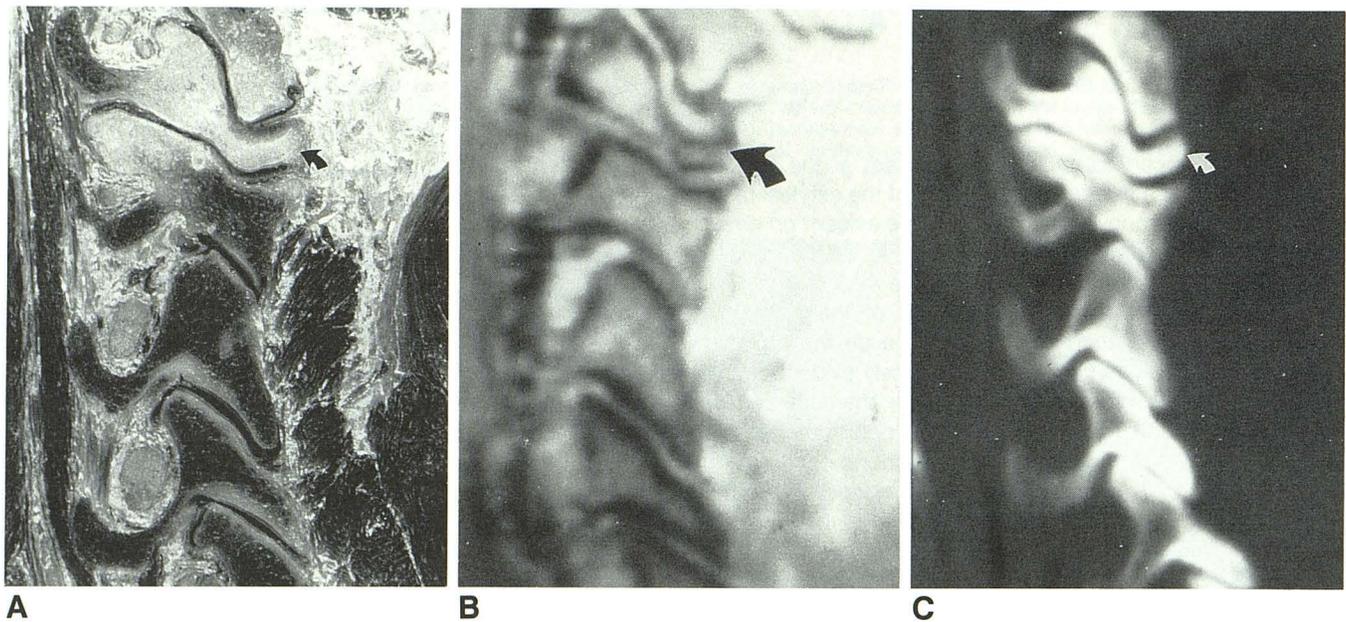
A–C, Degenerative changes in upper cervical facet joints. The cryomicrotome section (A) shows destruction of articular cartilage at C2–C3 and C3–C4 and deformity and sclerosis of the intervening articular pillar (curved arrow in A). MR image (B) shows a bright signal from the sclerotic marrow cavity (curved arrow) suggesting fatty degeneration of bone marrow in medullary space. CT scan (C) shows a density consistent with sclerotic bone (curved arrow).
